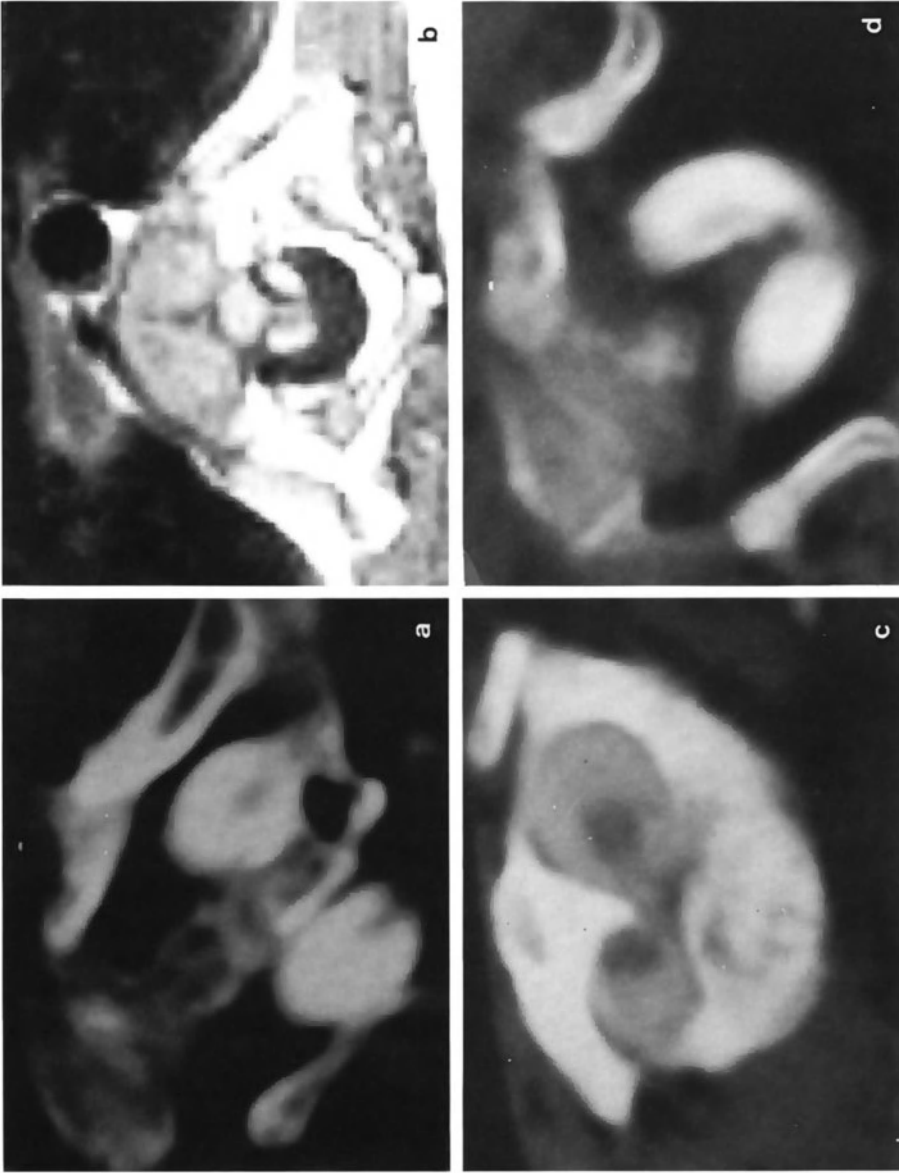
CT Metrizamide studies in four cases of diastematomyelia. (a) The two hemicords are totally separated by a large bony spur totally crossing the spinal canal. (b) The bony spur is thin and completely separates the two cords. (c) The hemicords are joined anteriorly. (d) The two hemicords are in one dural sac
